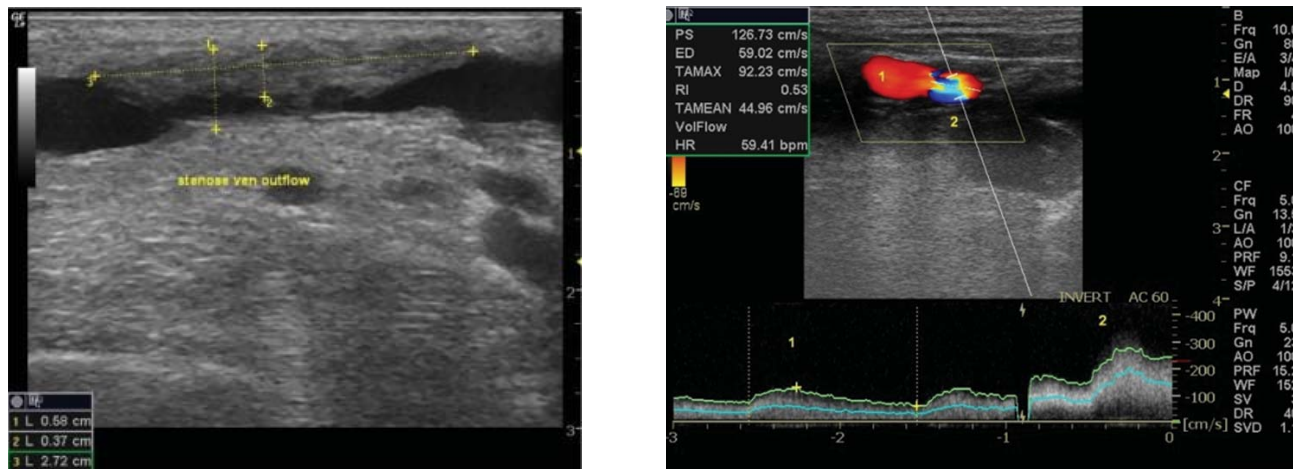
(a) B Mode appearance of high grade stenosis of venous outflow tract. (b) Colour and spectral doppler appearance of high grade stenosis of venous outflow tract, characterised by aliasing and increased blood flow velocities at the site of stenosis.
